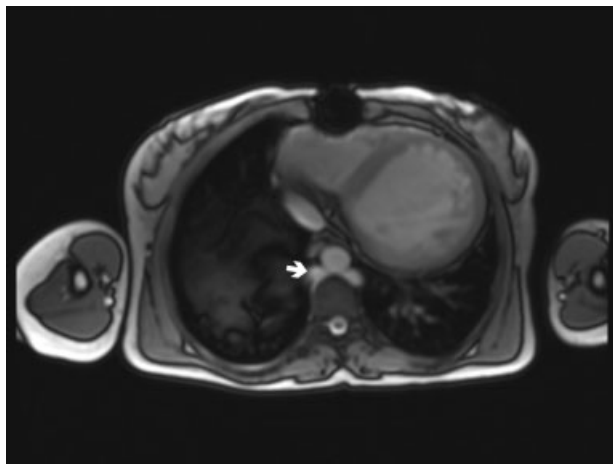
Magnetic resonance imaging of the azygos vein (white arrow) passing between the aorta and spinal column and conflues with the right superior vena cava (coronal view).
